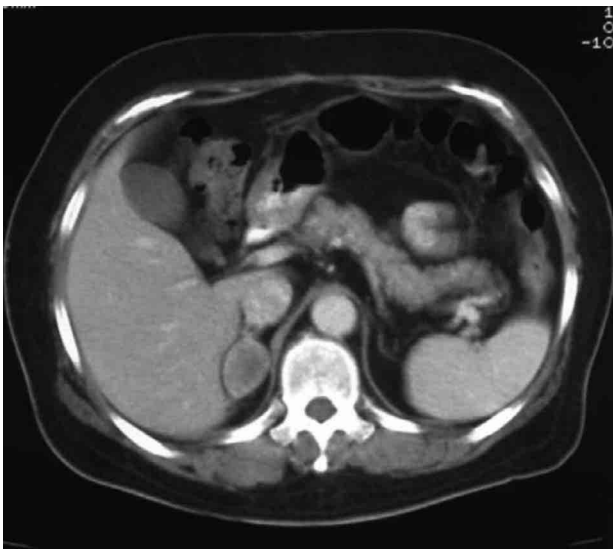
Surveillance computed tomography performed 14 months postoperatively, revealing a right adrenal tumor, 30 mm in diameter
